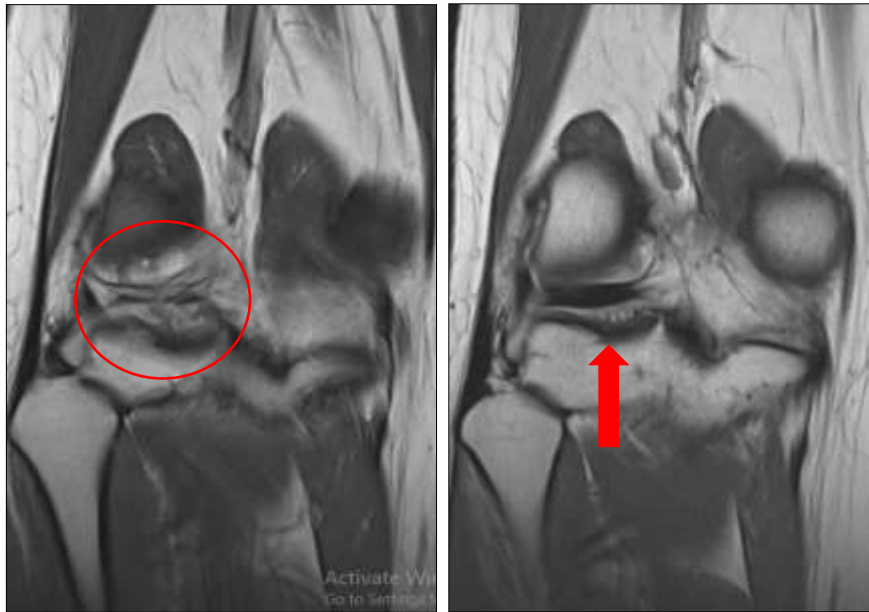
MRI image of right knee showing abnormal band on posterior aspect of lateral meniscus both above (circle) and beneath (red arrow) the meniscus
